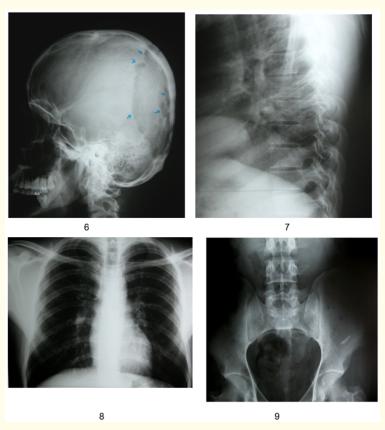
Radiographic X-ray Screening for detection about all boney lesions.
